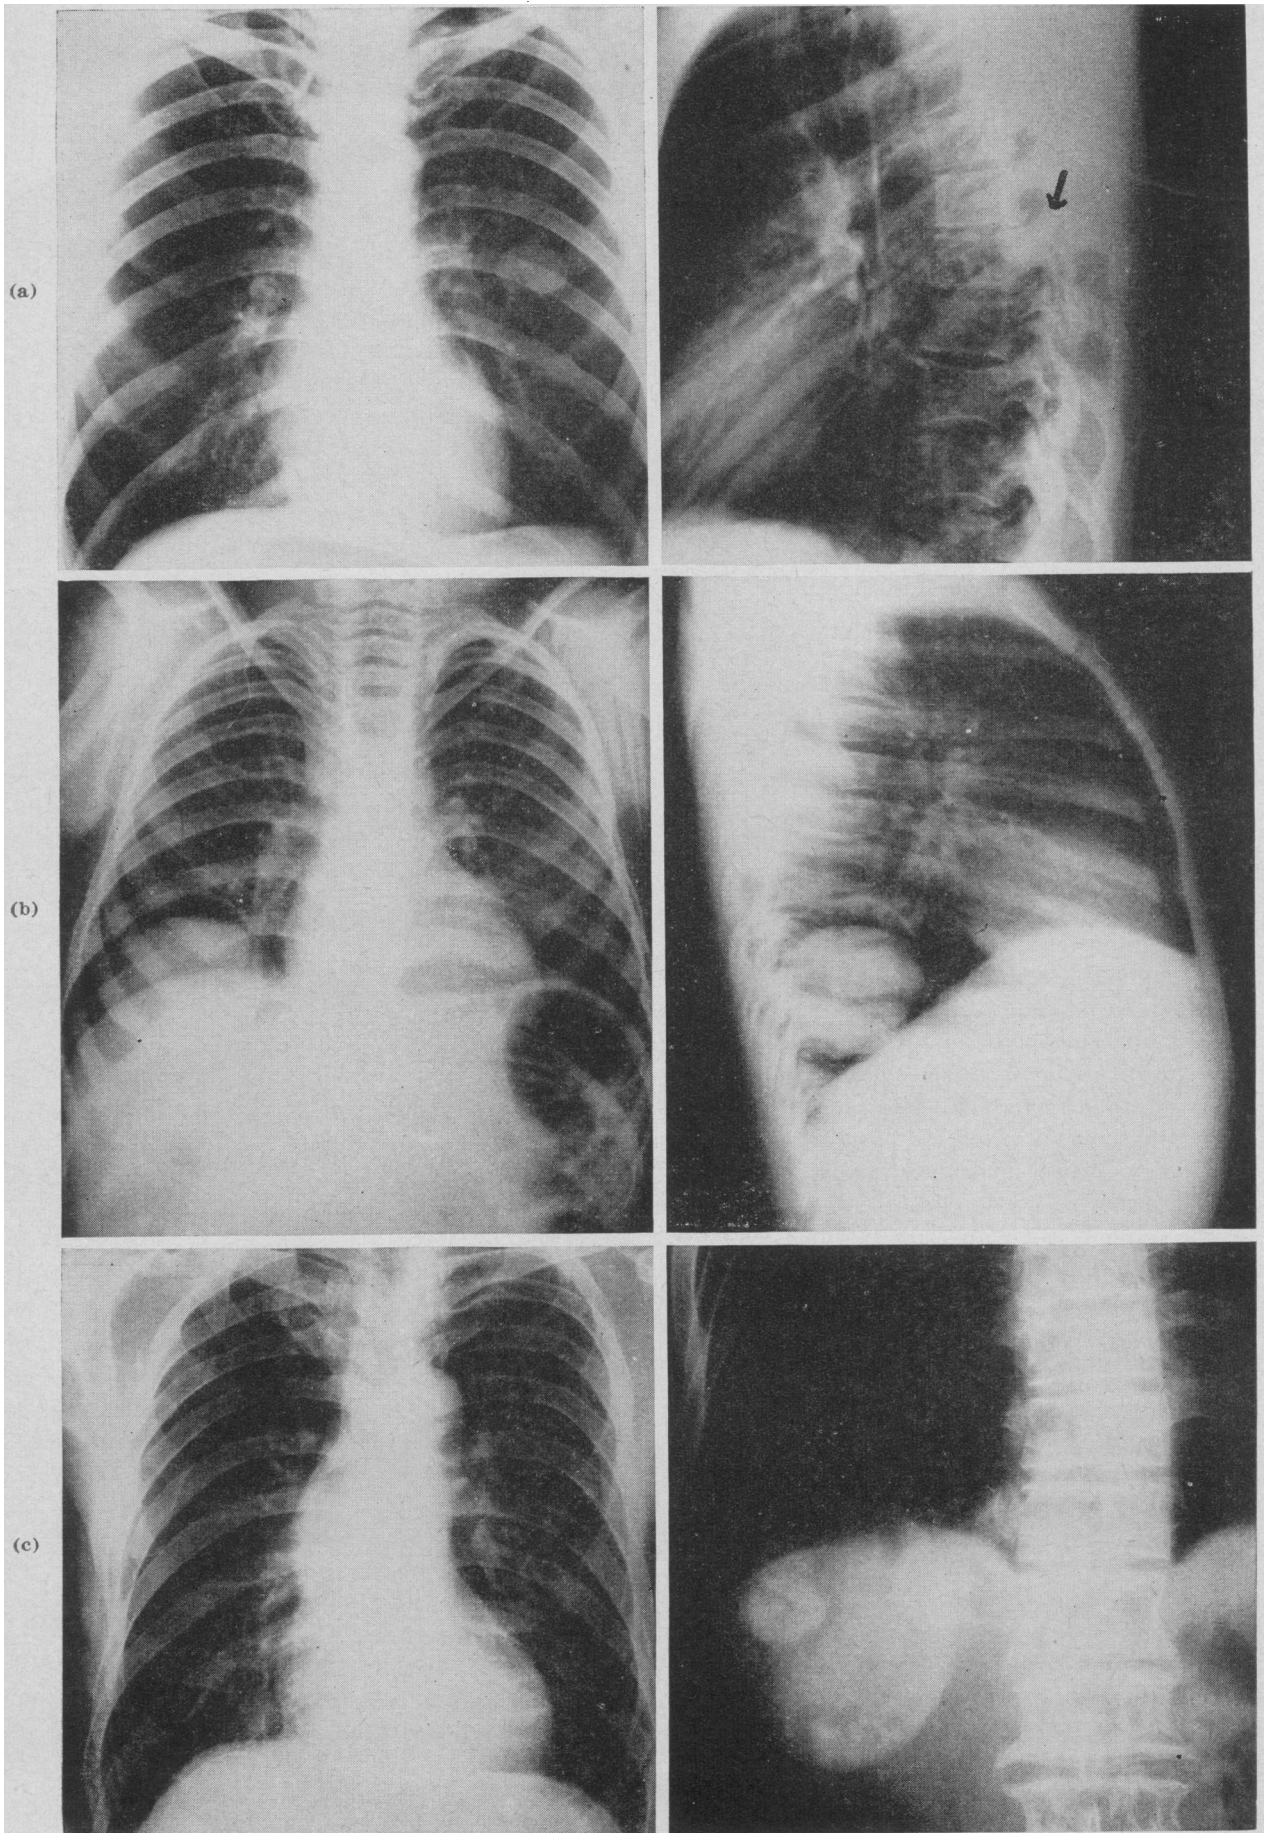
X-ray appearance of (a) simple hydatid cyst; (b) ruptured hydatid cyst (double arch formation); (c) calcified liver cysts as seen on films of the chest and the hepatic region.
